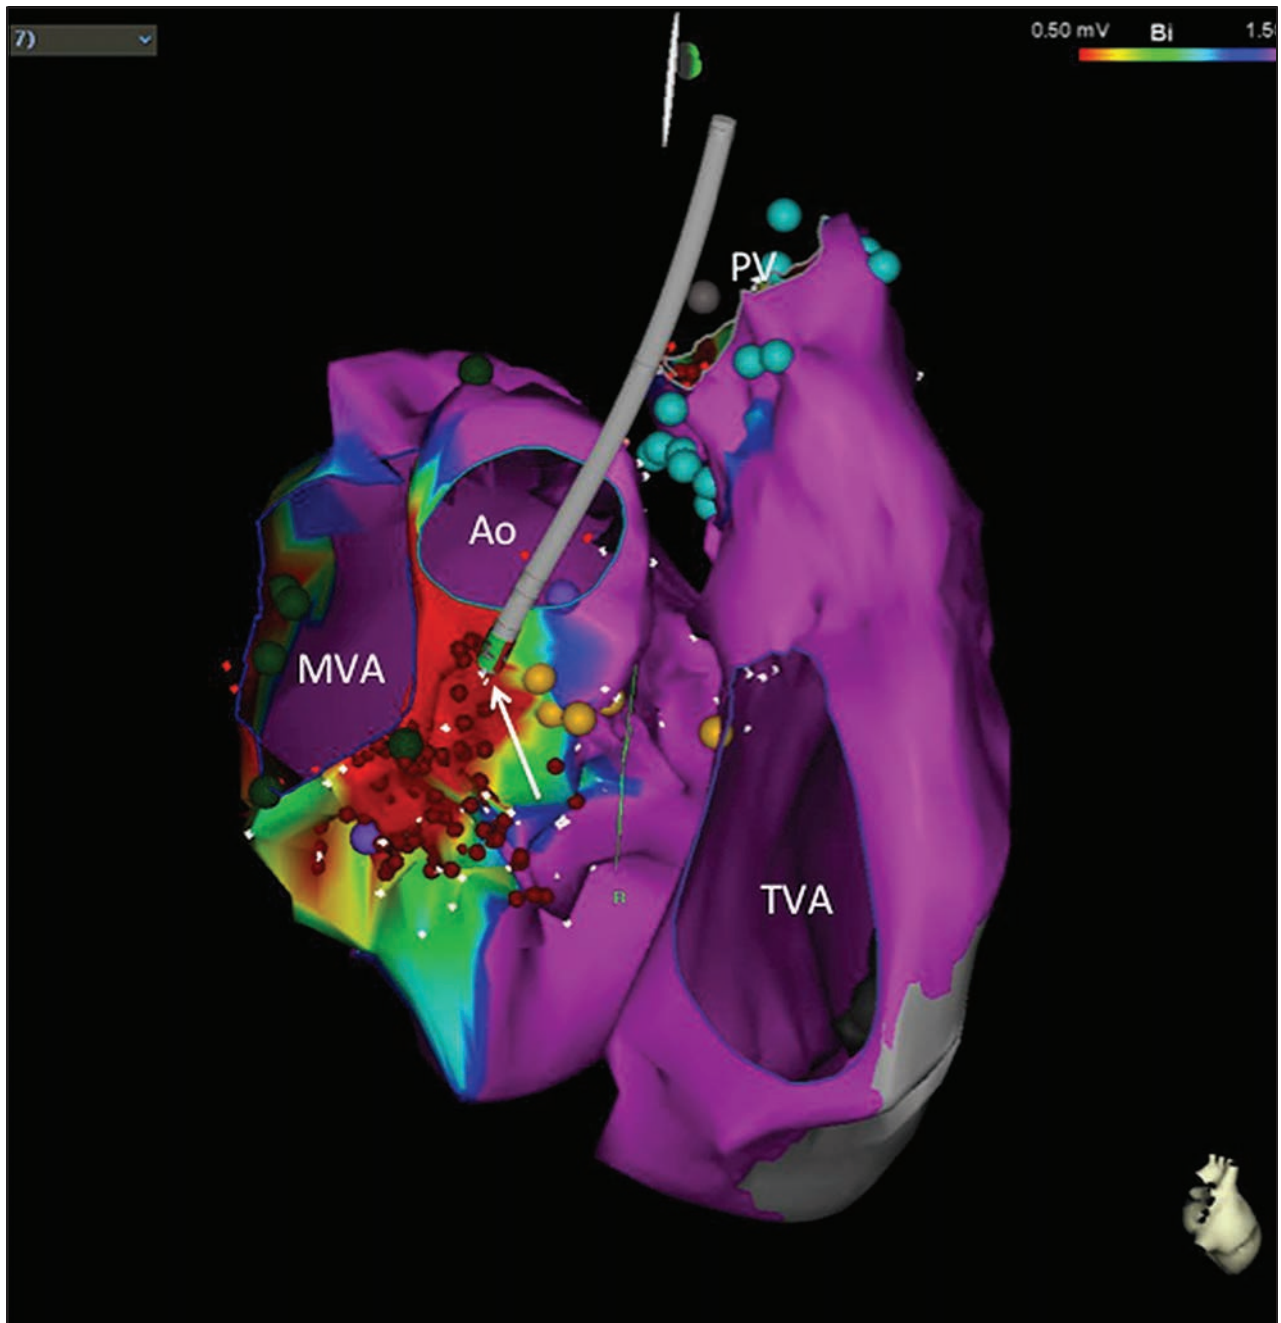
3D reconstruction of echocardiographic contours of the left ventricle from a posterior view showing the aortic valve (AV), the mitral valve annulus (MVA), and a superimposed voltage map. The catheter location with a matching pace map to the targeted VT (Figure 8-2) is indicated by an arrow. The pulmonic valve and tricuspid valve annulus (TVA) are also shown. Orange tags indicate the location of the bundle of His.
